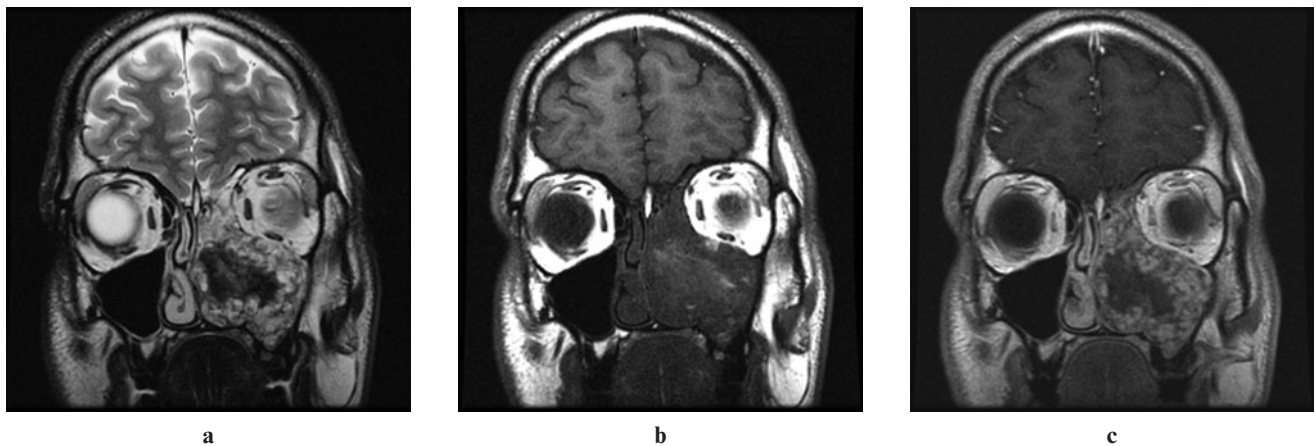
(a) Pre-contrast T_2 , (b) T_1 and (c) post-contrast T_1 MR images show a heterogeneous signal intensity mass (low T_2 and high T_1 centrally) centred in the left maxillary sinus with peripheral enhancement suggesting thick corrugated mucosa
